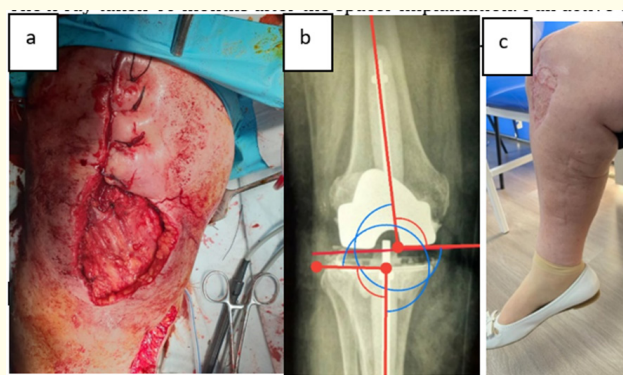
Intraoperative photo of the knee, X-ray and photo of the knee at the last follow-up.
